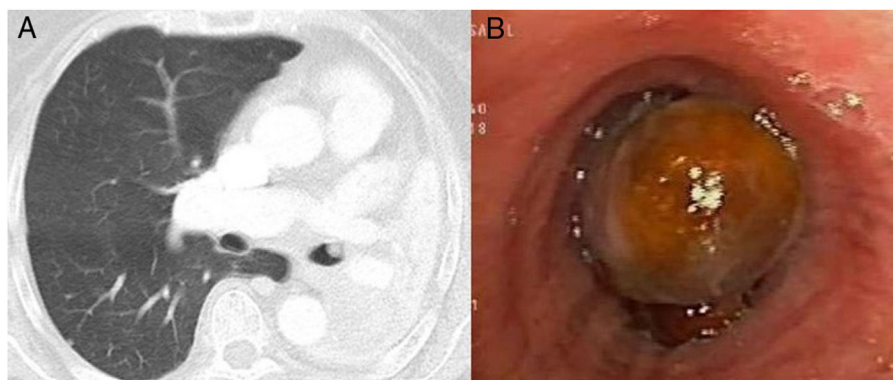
(A) Chest computed tomography showing endobronchial tumor in the LMB. (B) Flexible bronchoscopy showing a smooth, rounded, ochre-colored endobronchial lesion, 3.5 cm from the main carina, completely occluding the LMB.
